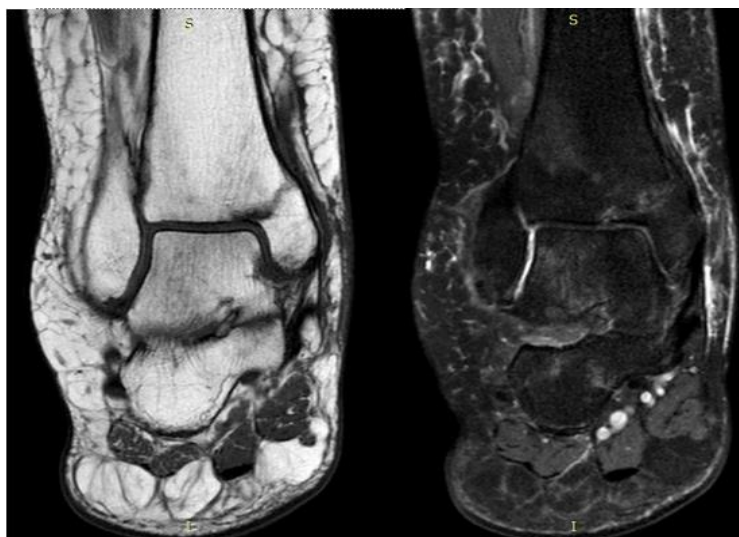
Non displaced linear fracture in 57 year male patient sustained trauma a year back presented with limited range of motion, coronal T1 and SPAIR image MRI showed linear hypo
